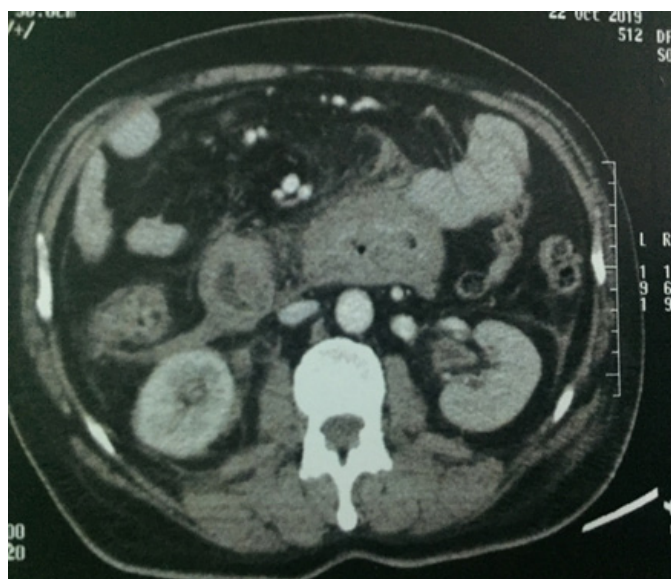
Abdominal CT scan: showing circumferential spontaneously hyperdense parietal thickening of the third duodenum and the Treitz angle.
